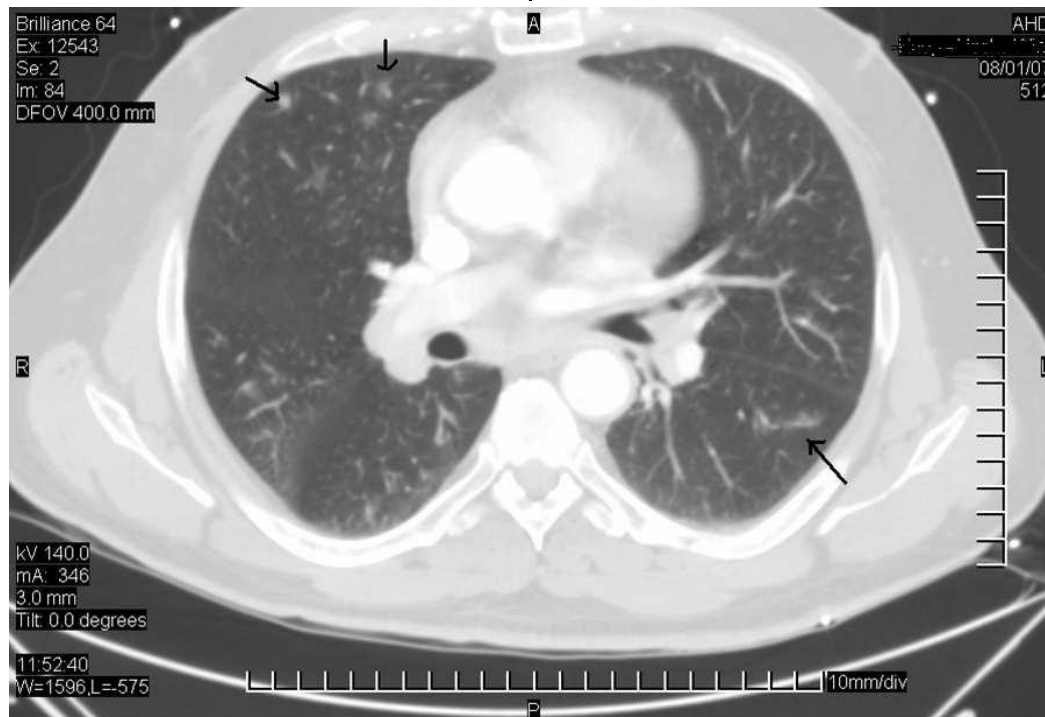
Chest CT scan showing patchy infiltrate in the RML, LUL and single pulmonary nodule in RML.
